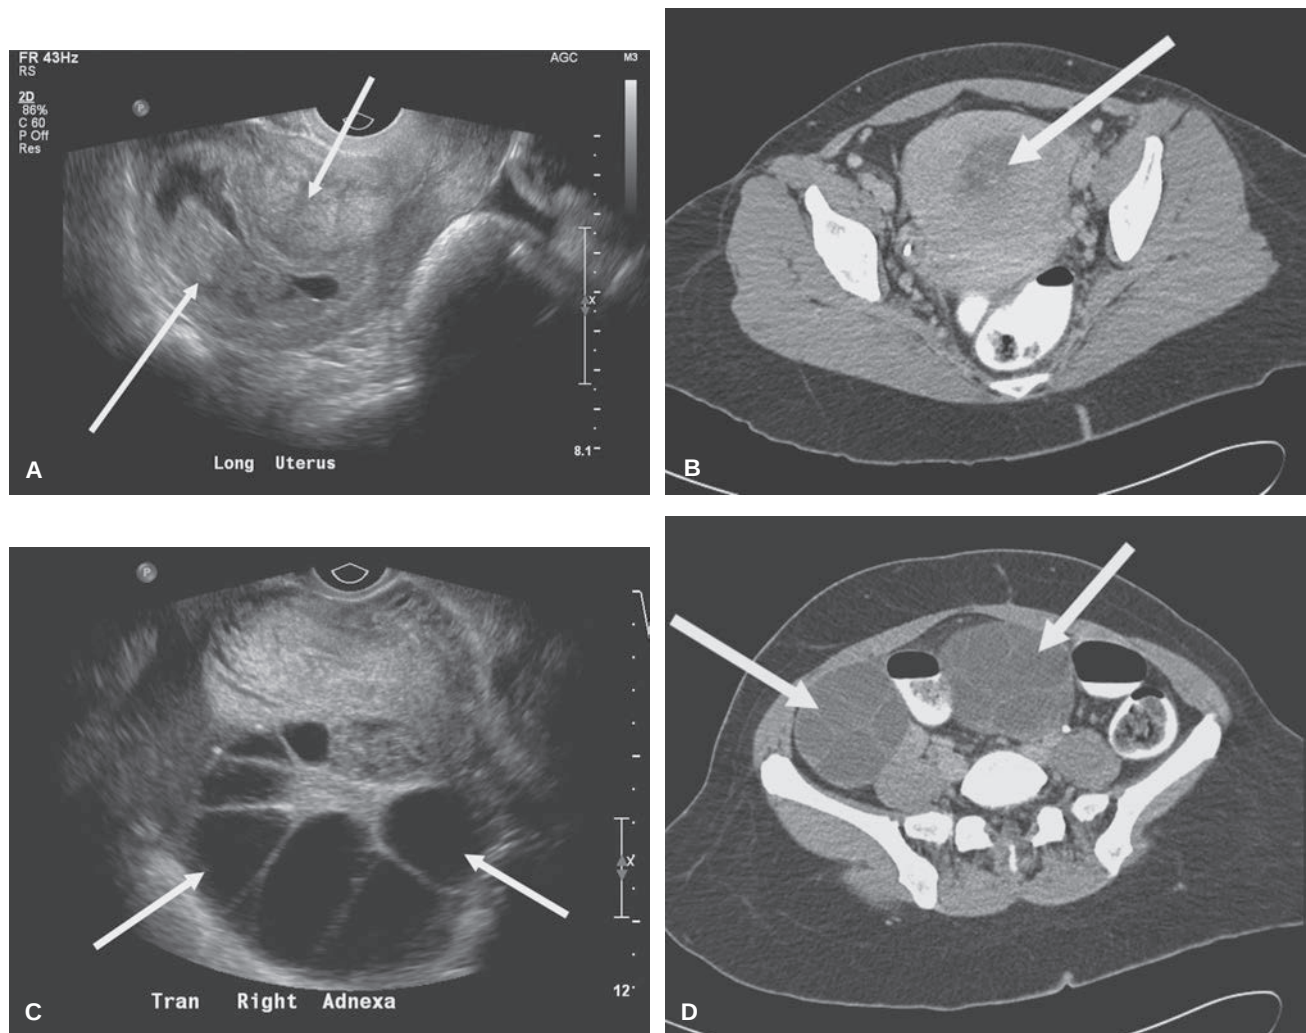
Hydatidiform mole. Gray scale sagittal ultrasound image of the uterus (A) demonstrates an echogenic, heterogeneous mass within the endometrial canal (white arrows in A). Axial contrast-enhanced CT image (B) in the same patient demonstrates enhancing soft-tissue distending the endometrial canal (white arrow in B). Gray scale ultrasound image (C) of the right ovary and contrast-enhanced CT image (D) through the pelvis in the same patient demonstrate bilateral enlarged ovaries with innumerable theca lutein cysts (white arrows in C, D).
